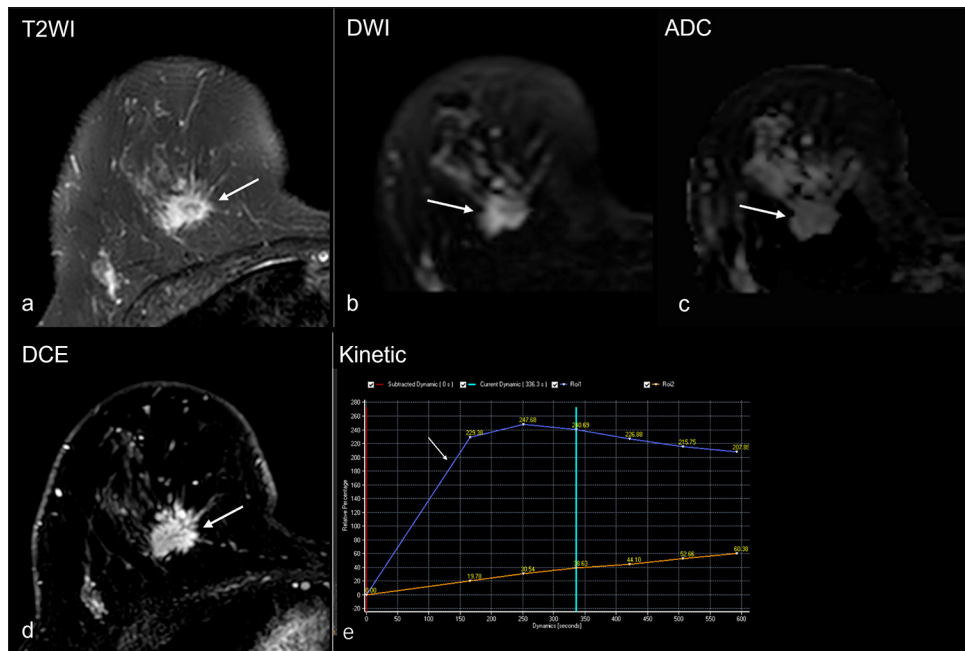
A 45-year-old woman diagnosed with invasive ductal carcinoma of the Luminal A subtype. (a) The lesion presents uneven low signal on T2-weighted imaging (white arrow), (b) uneven high signal on diffusion-weighted imaging (white arrow), (c) corresponding low signal on apparent diffusion coefficient (ADC) mapping (white arrow), the average ADC value is $0.71 \times 10^{-3} \text{mm}^2/\text{s}$. (d) The initial phase of dynamic contrast enhancement shows a heterogeneous internal enhanced mass with irregular shape and spiculated margin (white arrow), (e) the kinetic curve (white arrow) demonstrates a plateau appearance (type II curve). (T2WI: T2-weighted imaging, DWI: Diffusion-weighted imaging, DCE: Ddynamic contrast enhancement)
